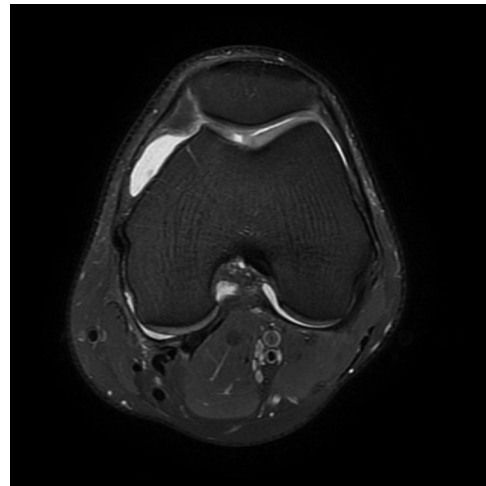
Axial section of a left knee magnetic resonance imaging showing a trochlear chondral lesion.
